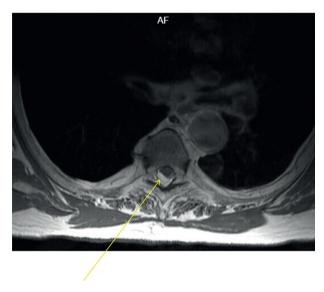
Axial section of gadolinium-weighted T1-weighted MRI showing lesional enhancement (yellow arrow), sign of greater compression on the right.
